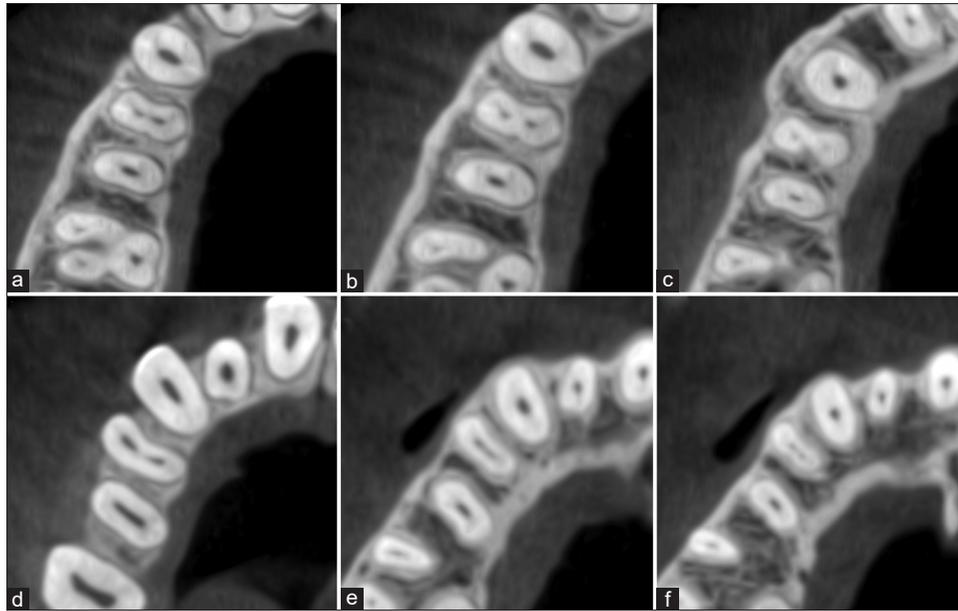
Cone-beam computerized tomography axial cross-sections showing different Vertucci configurations: Type IV in first premolar and Type I in second premolar (a) coronal third (b) middle third (c) apical third, Type VI in first premolar and Type I in second premolar (d) coronal third (e) middle third (f) apical third
